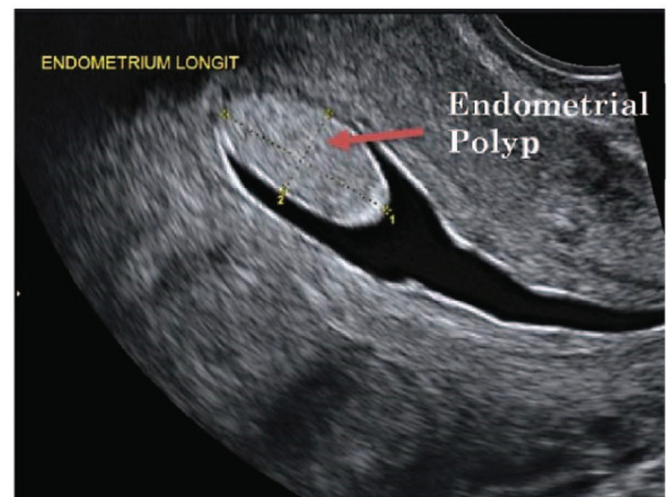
Transvaginal ultrasound: isoechogenic endometrial polyp. Distention of the uterine cavity produced after saline infusion.<sup>1</sup>
